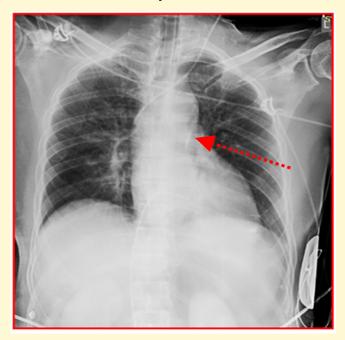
Frontal Chest Radiograph showing IABP insitu
